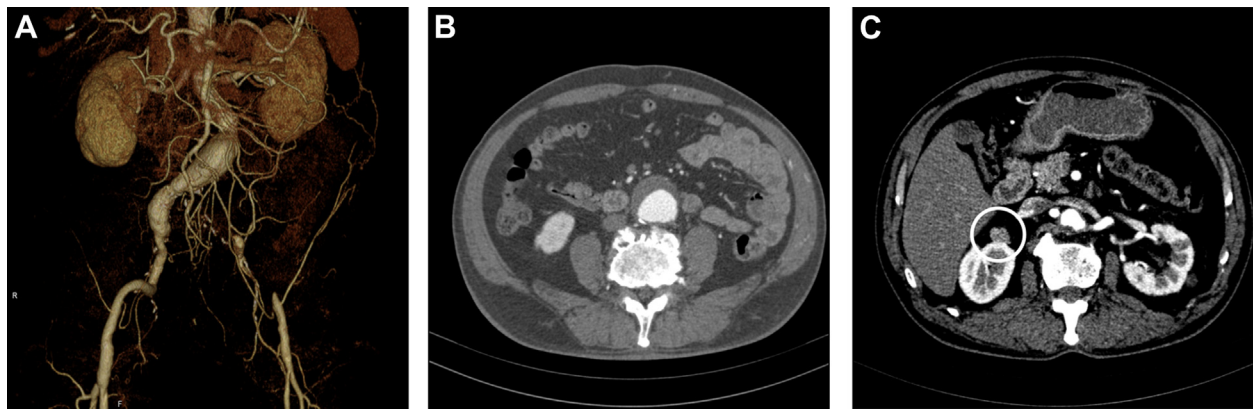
Preoperative computed tomography (CT) scans. (A) Reconstructed 3-dimensional CT scans show an abdominal aortic aneurysm (AAA) with concomitant occlusion from the left common iliac artery to the left
